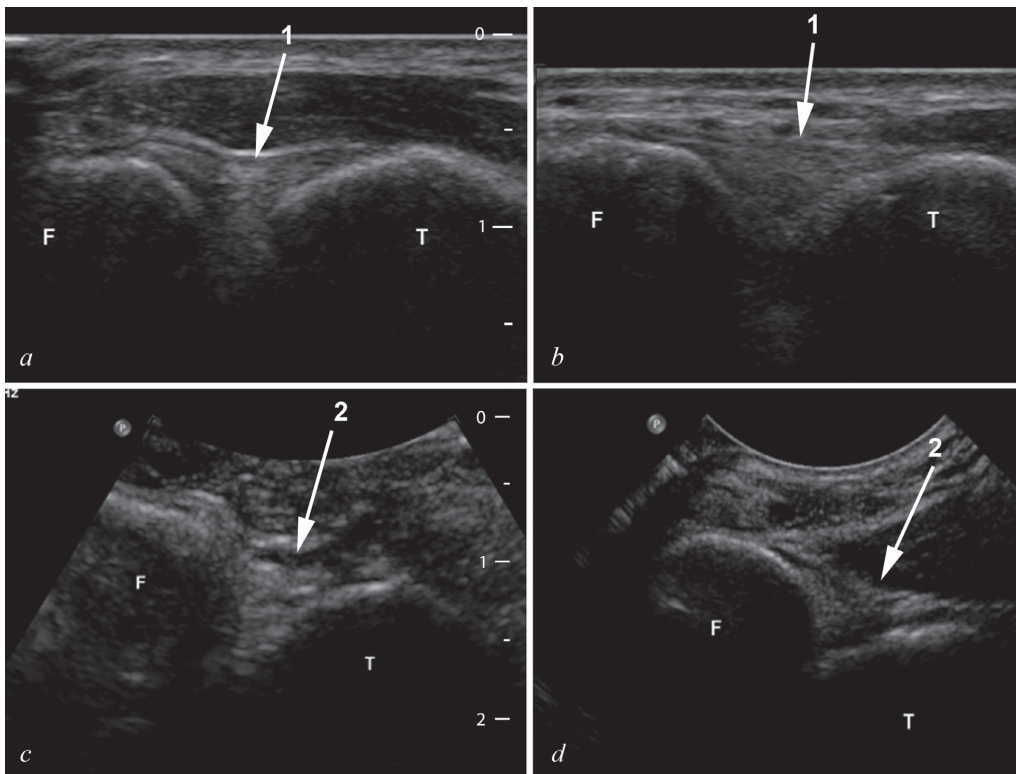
Ultrasound images of anterior (1) (*a*, *b*) and posterior (2) (*c*, *d*) tibiofibular ligament (female, 20 years). In plantar flexion the ATIFL is slack (*a*). In dorsiflexion the talus pushes the tibia and fibula outwards, with stretching of the anterior tibiofibular ligament as a result (*b*). The same mechanism applies for the PTIFL. In plantar flexion the ligament is slack with a resulting increase echogenicity (*c*). In dorsiflexion the fibres are stretched and are more longitudinally aligned (*d*). F, fibula; T, tibia.
